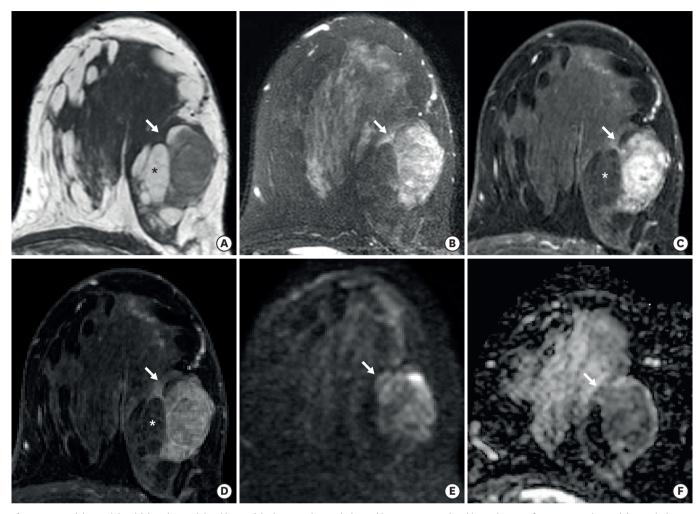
On axial T1-weighted (A) and T2-weighted image (B), the mass (arrows) showed heterogeneous signal intensity. Non-fat-suppressed T1WI (A) revealed hyperintense areas (asterisks) that did not show enhancement on post-contrast T1WI (C and D). Dynamic contrast-enhanced magnetic resonance imaging showed an oval-shaped irregular heterogeneously enhanced mass with a rapid enhancement in the early phase (C), followed by a delayed wash-out enhancement in the late phase (D). A focal area of the mass showed restricted diffusion on the diffusion-weighted image (E) and apparent diffusion coefficient map (F). T1WI, T1-weighted image.
